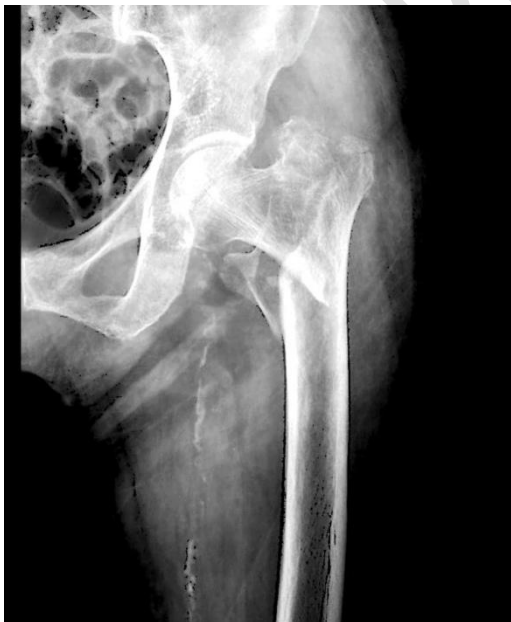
Shows preoperative X-ray of Neck of femur fracture
